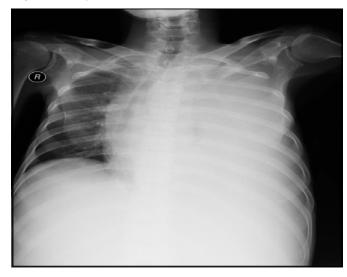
Chest x-ray AP view suggestive of left sided pleural effusion.
